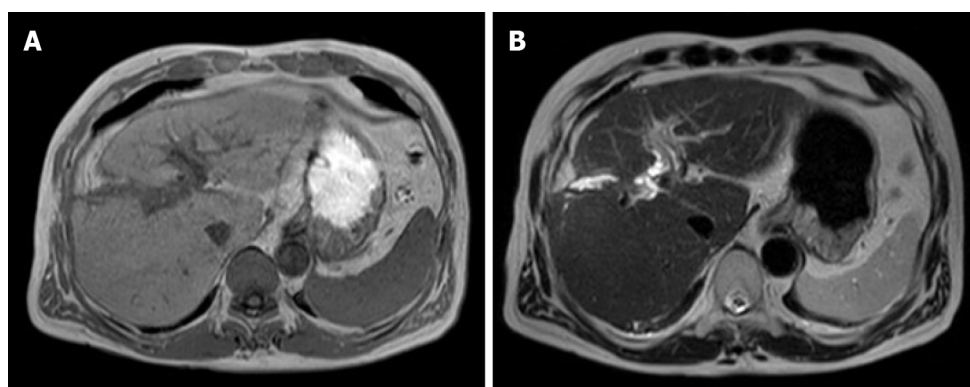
Magnetic resonance imaging findings at 5 mo before the second operation. There was no evidence of the recurrent tumor on the magnetic resonance images. A: T1 image; B: T2 image.
